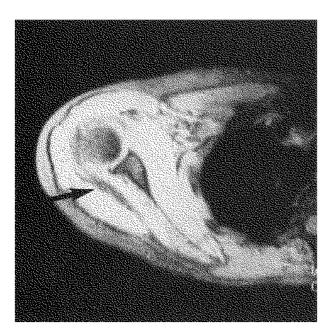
MRI of the left shoulder showing an abnormal band in the infraspinatus muscle.
